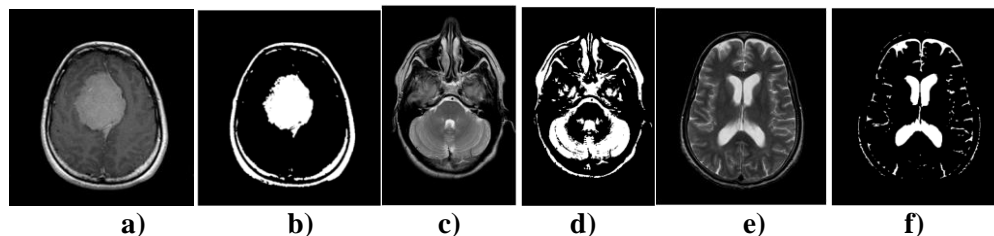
18 Thresholding algorithm applied to MRI slice. a) original image, b) thresholded image, c) original image, d) thresholded image, e) original image, f) thresholded image.
